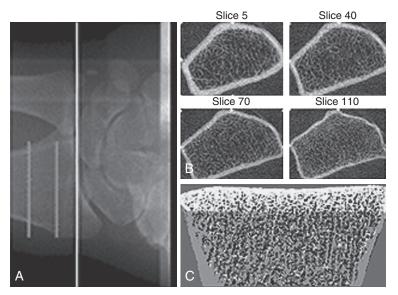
High-resolution peripheral quantitative computed tomography. (A) Radiograph of distal radius; *lines* indicate the section analyzed. (B) Representative cross-sectional images from computed tomography slices. (C) Representative three-dimensional image. (Modified from Khosla S, Riggs BL, Atkinson EJ, et al: Effects of sex and age on bone microstructure at the ultradistal radius: a population-based noninvasive in vivo assessment. J Bone Miner Res 21:124–131, 2006.)
